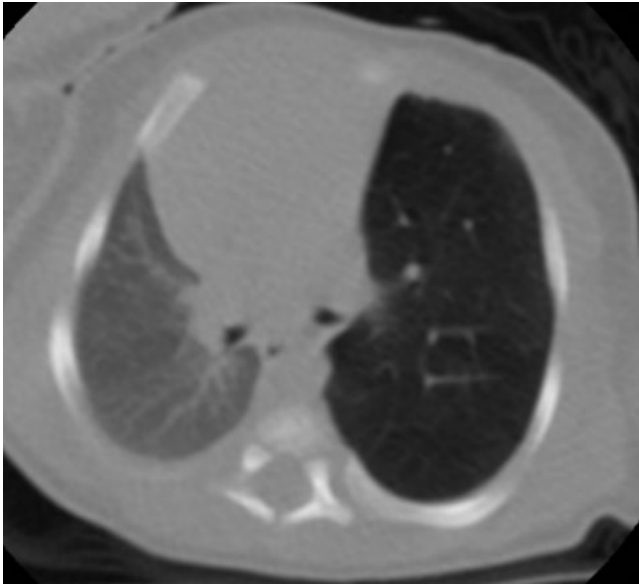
Chest CT of an infant with congenital lobar emphysema complicated by hyperinflation and mediastinal shift.
